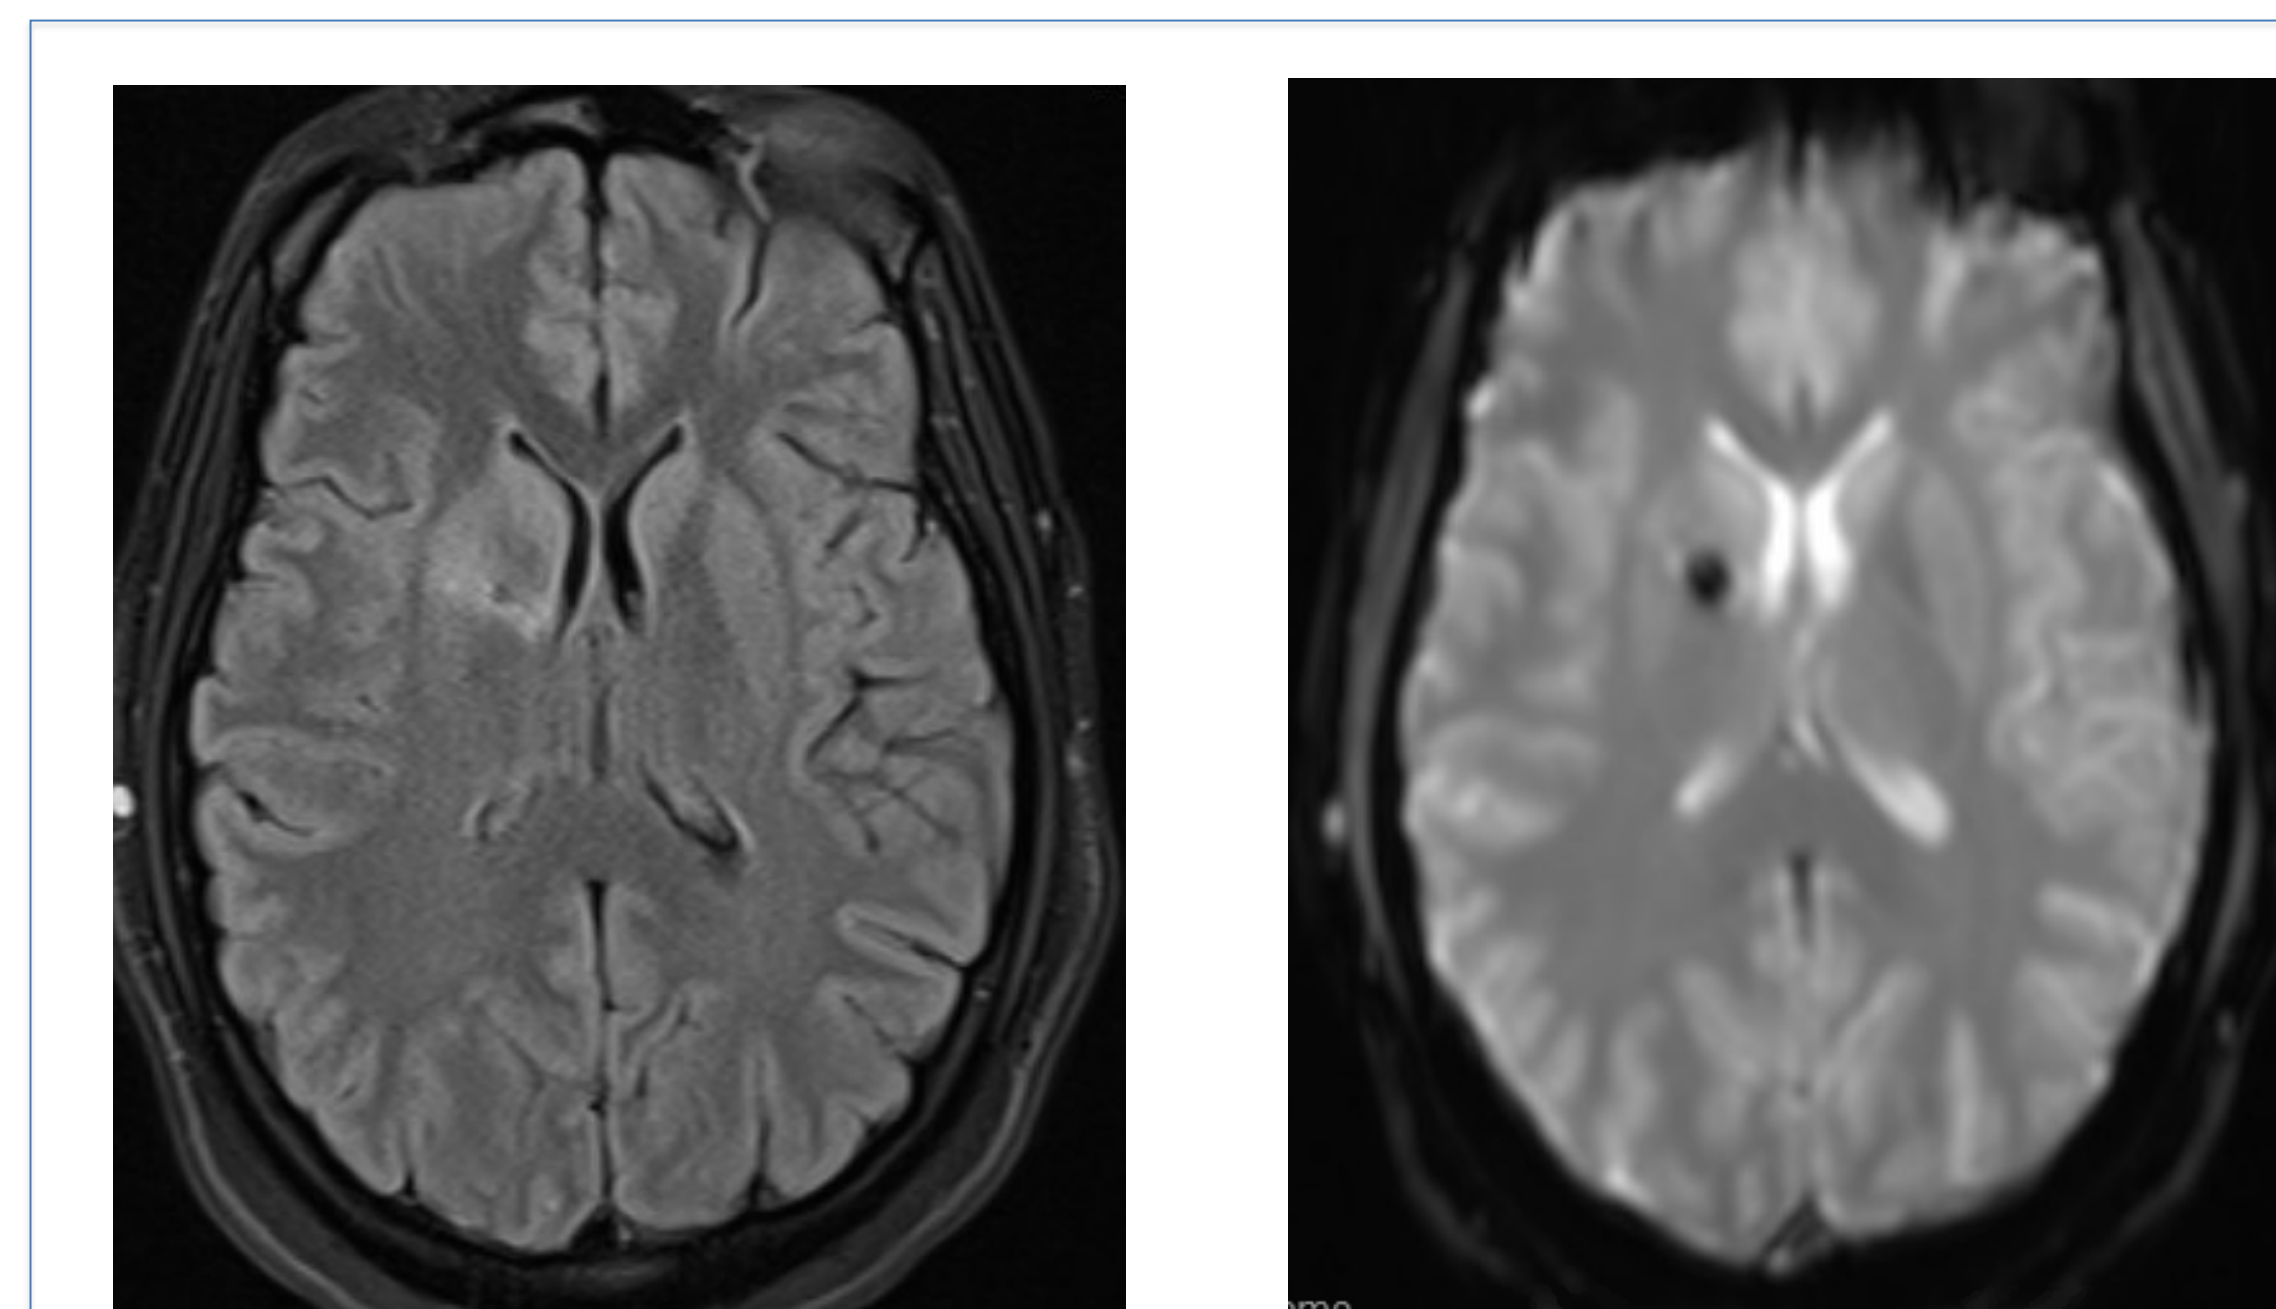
hemorrhage in Internal capsule (FLAIR and GRE sequences)
